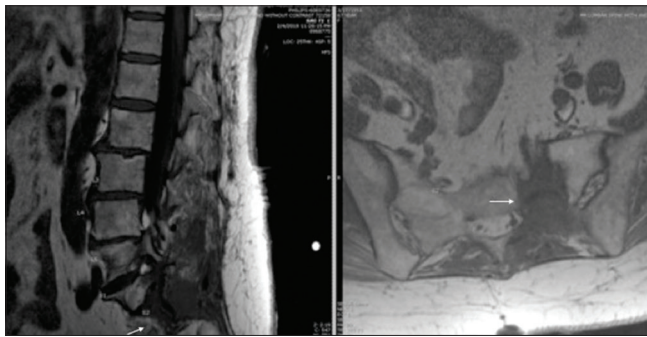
Postoperative sagittal and coronal non-contrast MR images demonstrating total resection of the pre-sacral schwannoma as well as postoperative changes. White arrow points to resection cavity.
